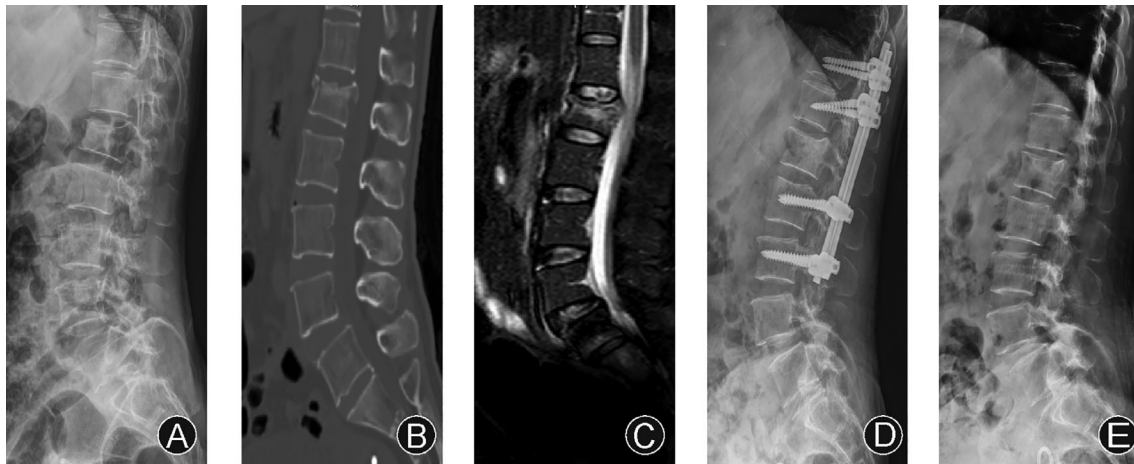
Typical case one. A 55-year-old female patient suffered L1 compression fracture because of accidental fall. She took the surgery by MR combined with pedicle fixation through WPA. (A) The lateral X-rays showing the wedge shape of L1. (B) Sagittal CT showing the fracture on L1, especially on the upside of L1. (C) Sagittal MRI T2-weighted image showing the hypointense on L1 and indicated the L1 fracture. (D) The postoperative lateral X-rays showing the restored height of L1 vertebra. (E) The follow-up lateral X-ray also showing the satisfactory height recovery of L1 vertebra after the remove of screws-rods fixation.
